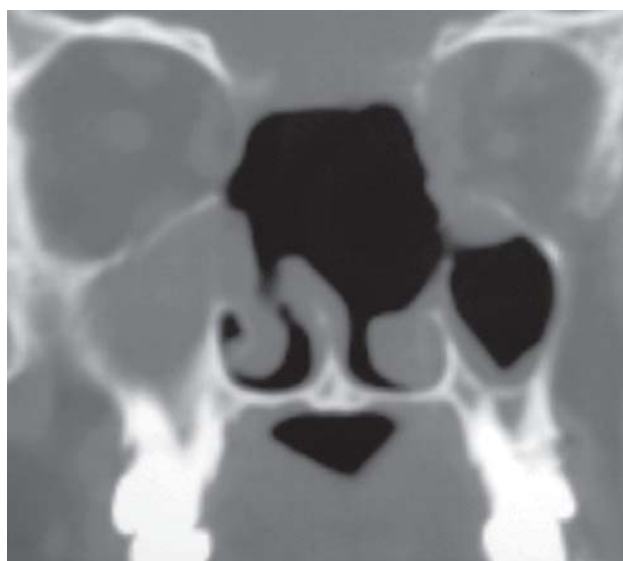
Postoperative CT photograph showing complete disease clearance
